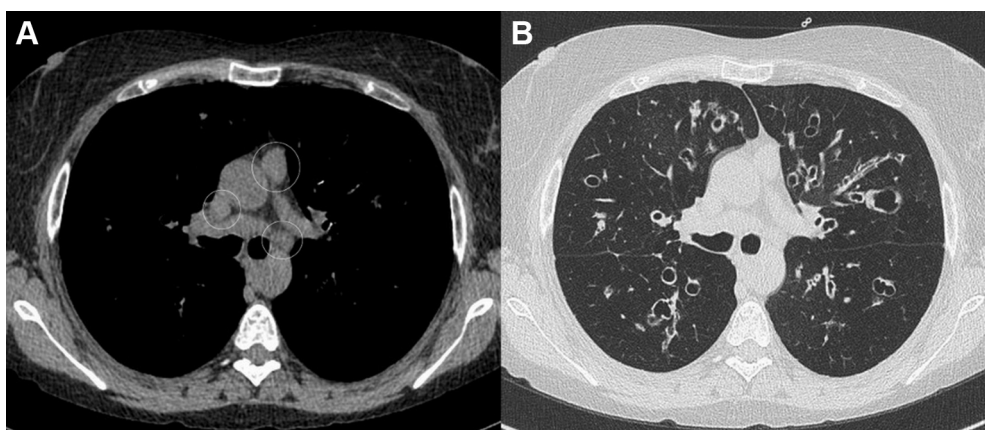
A, B, Axial high-resolution CT scans of the chest in a patient with cystic fibrosis revealing mediastinal lymphadenopathy (circled in A).
